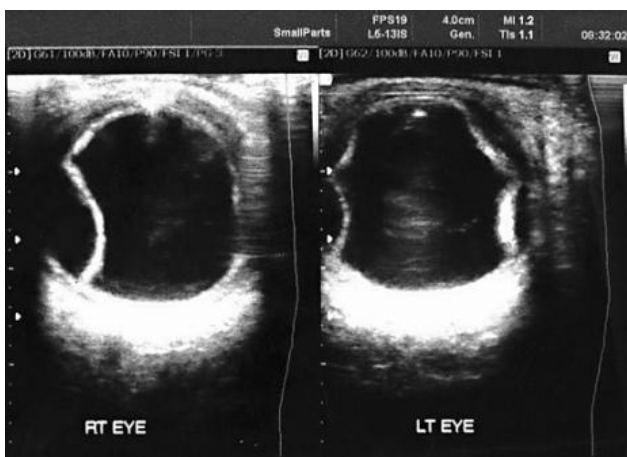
B scan ultrasonography confirming massive choroidal detachment in both eyes⁽¹⁴⁾
